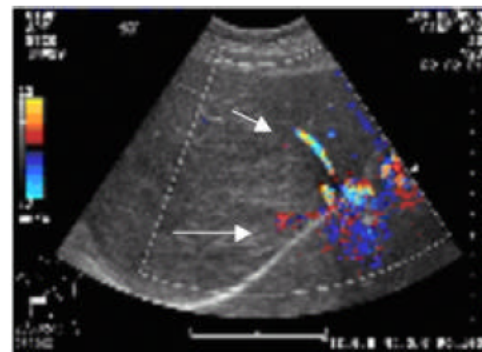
Doppler sonography: A hyper-echoic mass in the right lobe of the liver. The right hepatic vein was merged in the mass (long arrow). The middle hepatic vein was very close to the mass (short arrow)
